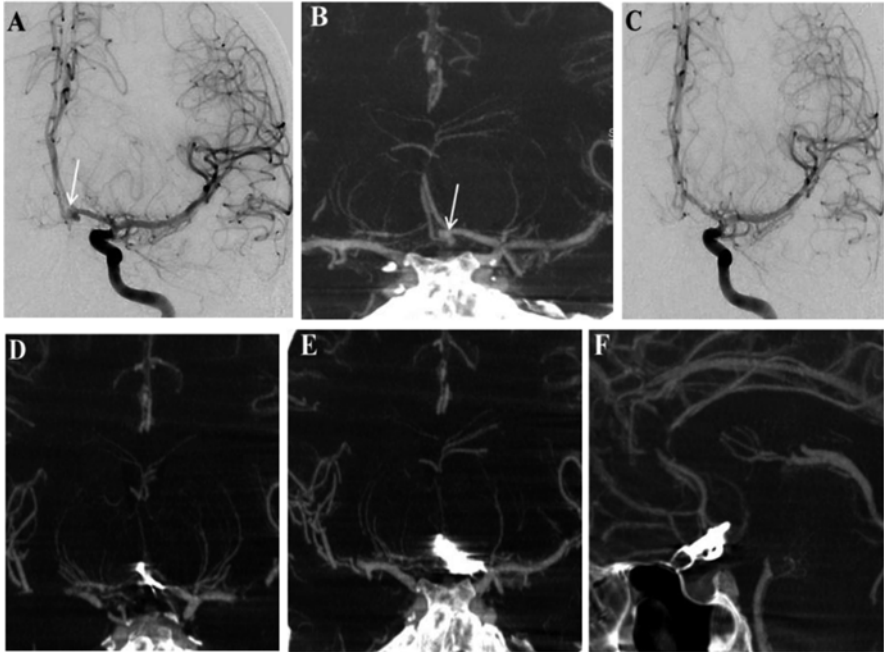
IV FDCT for the assessment of vasospasm after aneurysm clipping. A 22-year-old male was transferred for subarachnoid hemorrhage. Initial DSA and IV FDCT reveal aneurysmal dilatation (*arrow*) of the anterior communicating (A-com) artery (a and b). On the 5 days after operation, confused mentality with increased transcranial Doppler velocity was observed. DSA shows no significant luminal narrowing of the vessels compared with those of initial images of DSA (c). Selective coronal and sagittal IV FDCT MIP images demonstrate no significant vasospasm which is consistent with DSA (d-f) [34]
